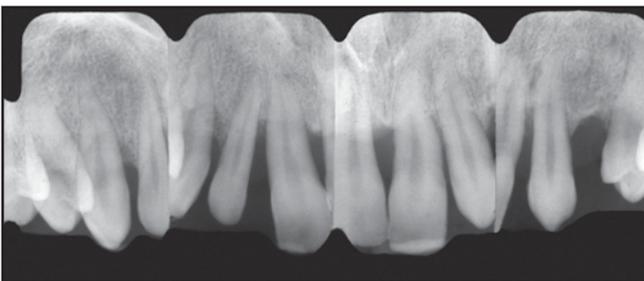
Radiograph prior to orthodontic-microsurgical treatment.*
